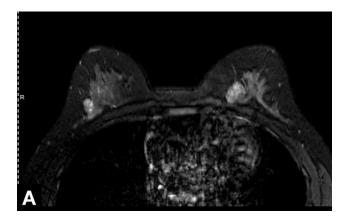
(A, B). Breast FA on MRI – Hypersignal in T2 sequence (A) with benign enhancement (B).
